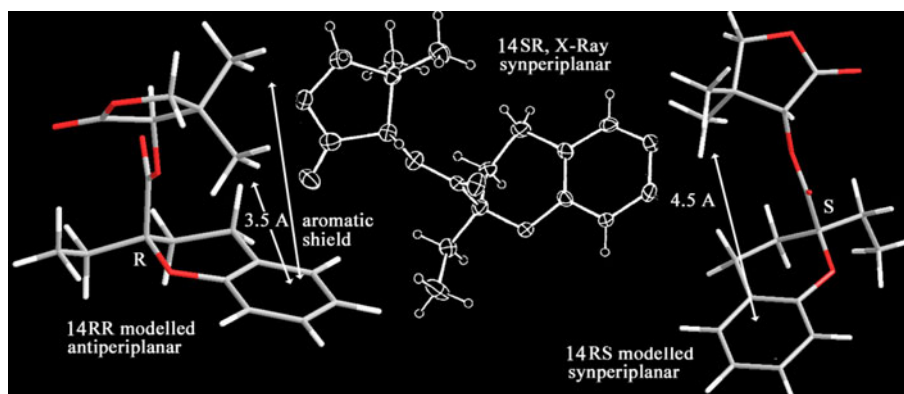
Modelled and X-Ray structure of pentolactone esters 13 and 14.
